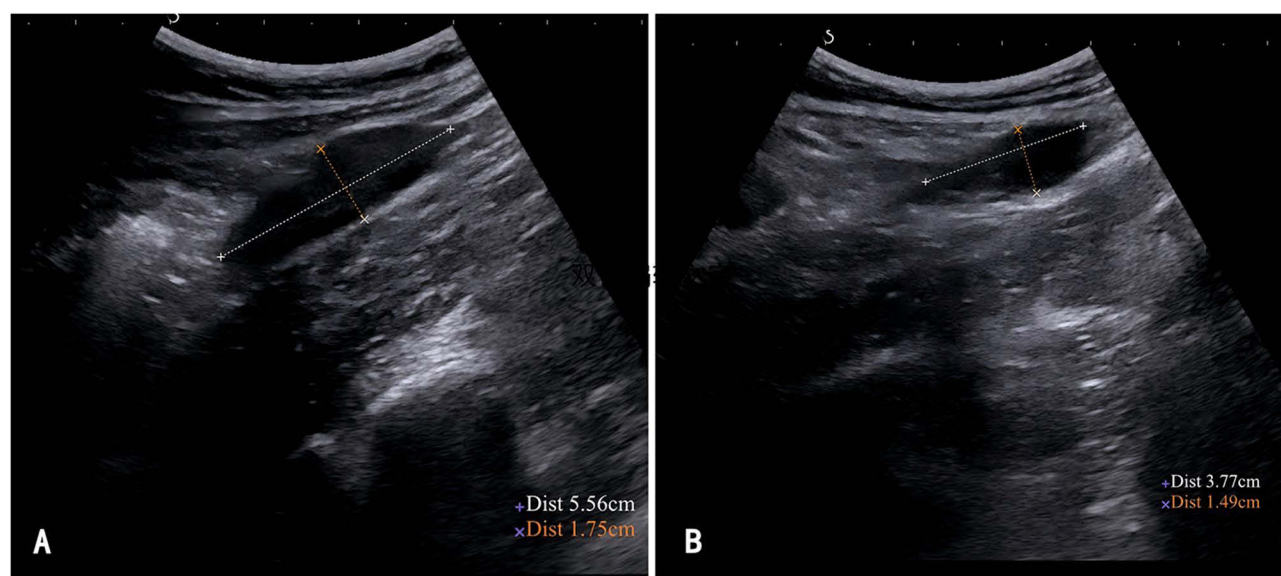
(A) Ovarian ultrasound image. (B) Inguinal region ultrasound image.
